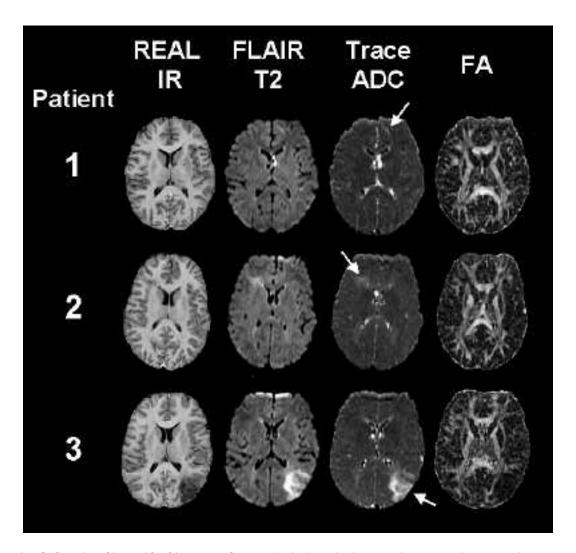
Imaging findings in subjects with white matter changes. Axial T1 weighted (acquired using a real constructed inversion recovery (IR) sequence), FLAIR (T2), mean apparent diffusion coefficient (trace ADC) and fractional anisotropy (FA) maps for representative single slices of the three patients with high T2 signal abnormalities in the subcortical white matter. Patients one and two have typical translaminar FCD (patient one-left frontal, patient two-right frontal) with thickened cortical grey matter, blurring of the grey-white junction and high T2 signal abnormalities of the white matter that extends from the cortex to the lateral ventricle. Patient three has a large left parietal-occipital lesion with thickened gyri and extensive subcortical white matter T2 hyperintensity. Note the elevated mean diffusivity (i.e. given by trace ADC) and the reduced structural orientation (i.e. given by fractional anisotropy, FA) of the underlying subcortical white matter.
